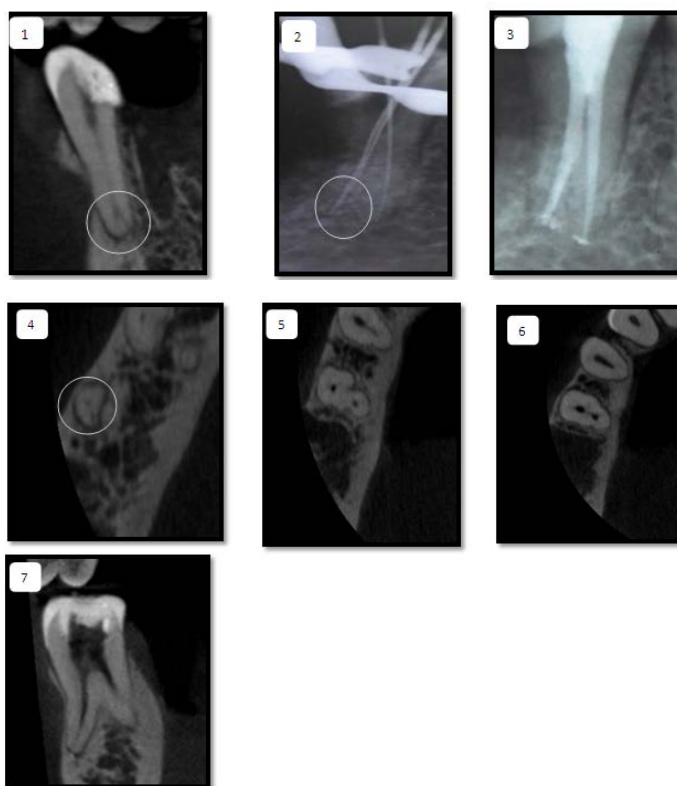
1) CBCT section showing apical delta with buccal root; 2) IOPR x-ray showing apical delta in buccal root, two k files in same root one in main canal and another in accessory canal; 3) obturated apical delta; 4) CBCT transverse section of buccal root showing one main
